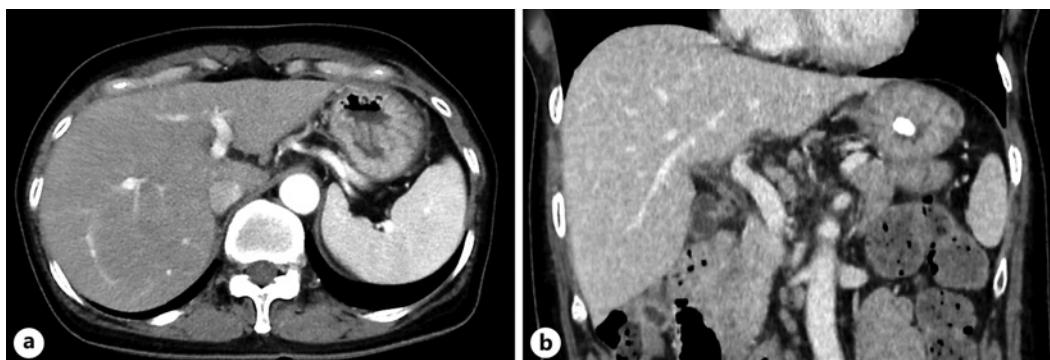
Computed tomography did not reveal any abnormalities, hepatomegaly, or splenomegaly. No abnormalities in the hepatobiliary system were observed (a: horizontal view, b: coronal view).
